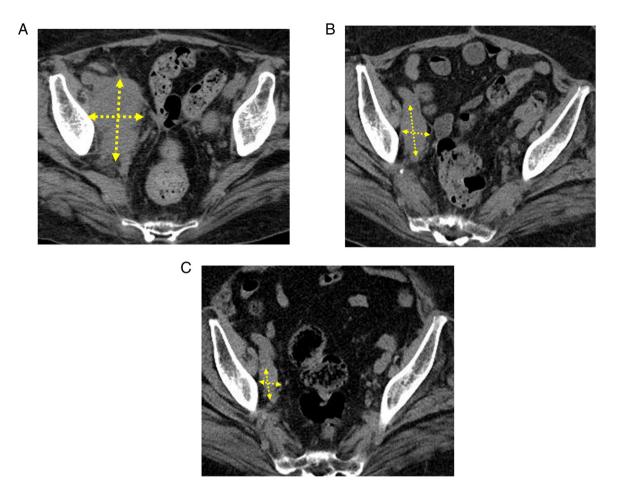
Computed tomography findings revealed a durable response after the discontinuation of pembrolizumab monotherapy. (A) Right pelvic lymph node metastases after the AP regimen. (B) Right pelvic lymph node metastases after 7 cycles of pembrolizumab monotherapy. (C) Right pelvic lymph node metastases decreased in size 18 months after the discontinuation of pembrolizumab. Yellow crossed arrows indicate the metastatic pelvic lymph nodes. AP, doxorubicin and cisplatin.
